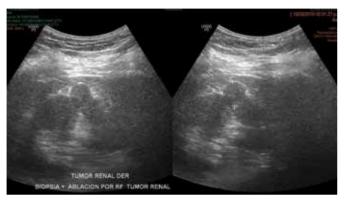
Planning of renal biopsy and radiofrequency ablation under ultrasound guidance.
